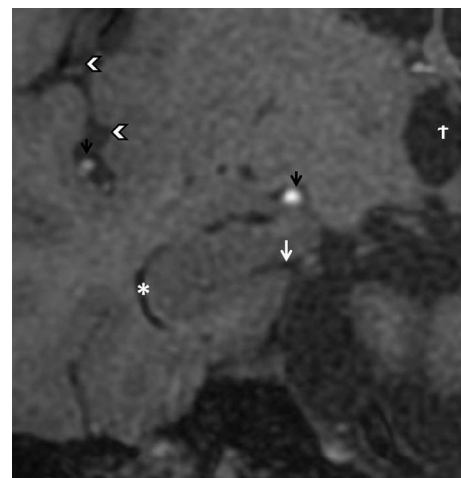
Magnified coronal T1-weighted image of a 48-year old non-demented control object revealed right hippocampal sulcus (vertical white arrows) and choroidal fissure (asterisk) within normal limits. The right Sylvian fissure (white arrowheads), third ventricle (dagger) and branches of anterior and middle cerebral arteries (vertical black arrows) were also seen
